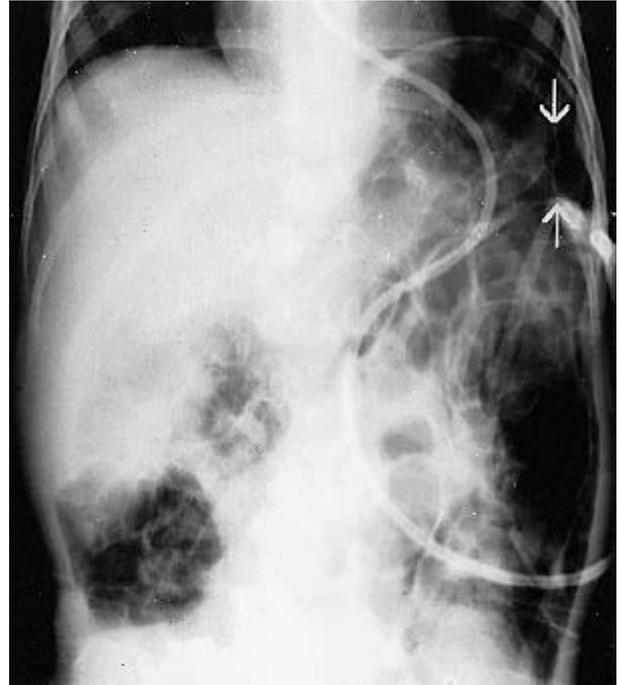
Supine abdominal X-ray film. Pneumoperitoneum manifested by a triangular pocket of air in left upper quadrant (arrows) outlining outer wall of adjacent bowel (double wall sign).
